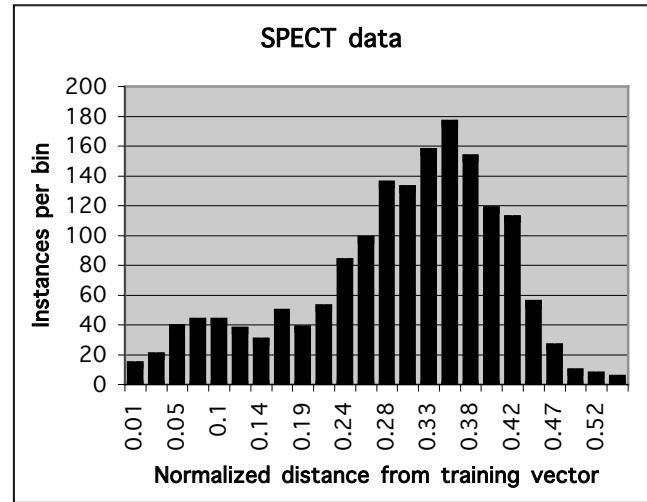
One distribution was markedly different from all the others. Above is the distribution of distances of candidate memory cells from the training antigens for the SPECT data set.
